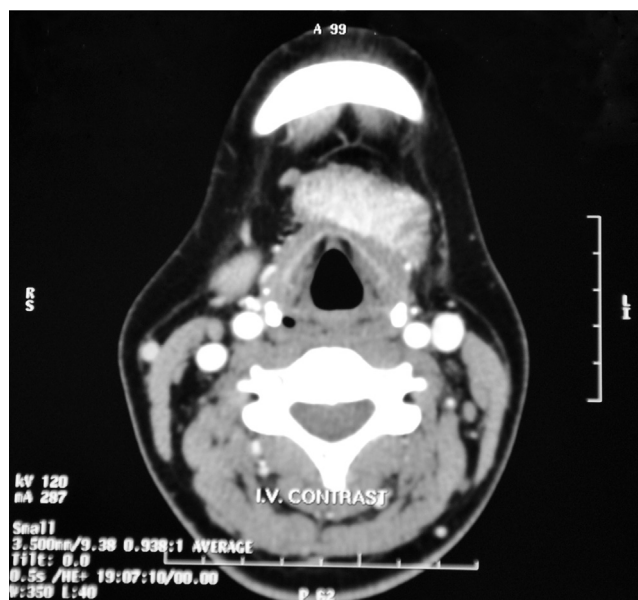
(Axial view) Preoperative post contrast computed tomography scanning of the soft tissue of the neck showing a mid-line pre-hyoid neck mass, highly enhancing, deep to the platysma muscle, and attached to the infra-hyoid muscles.
